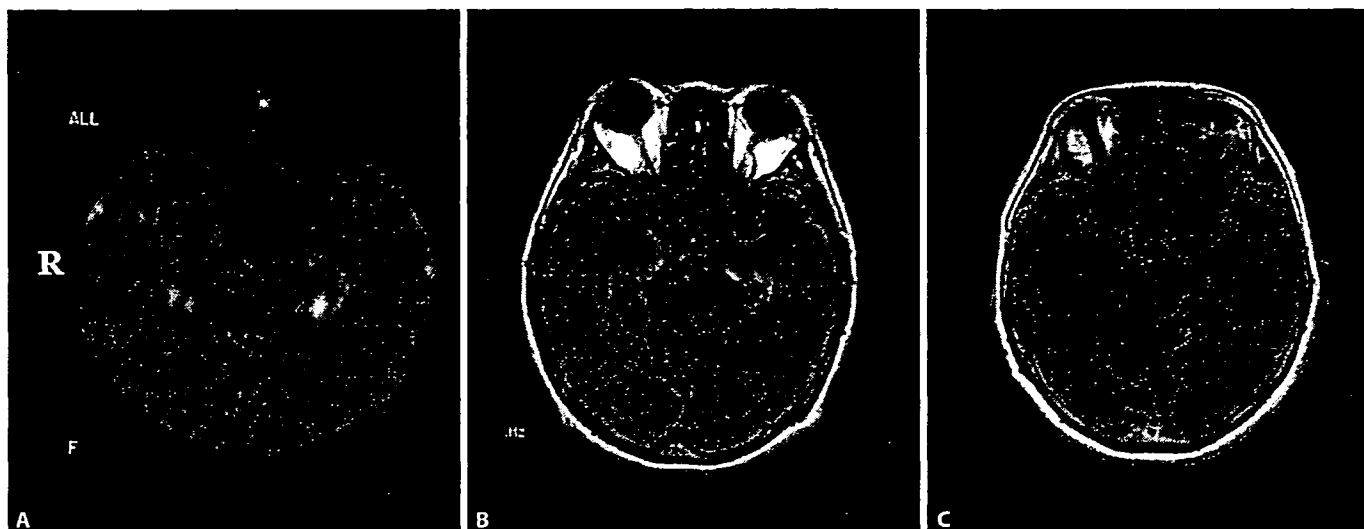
MR images of patient 1. An axial diffusion-weighted image (A) and a fluid-attenuated inversion recovery image (B) show hyperintensity in the bilateral mesial temporal lobes in the acute phase (2 days after admission). C A follow-up T₁-weighted MR image shows the disappearance of signal abnormalities and the appearance of bilateral hippocampal and mild cortical atrophies (1 year after the disease onset).
